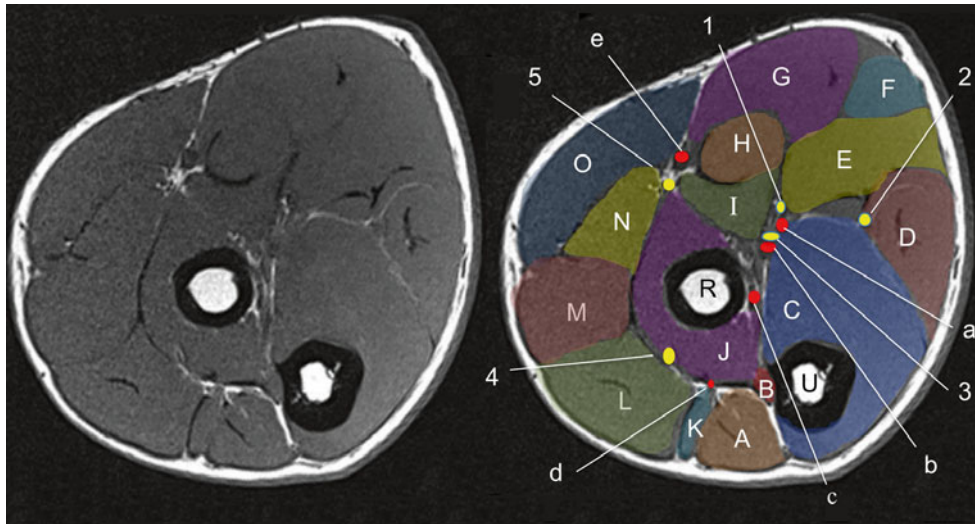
MRI axial image of the distal forearm. A anconeus muscle, B biceps tendon, C flexor digitorum profundus muscle, D flexor carpi ulnaris muscle, E flexor digitorum superficialis muscle, F palmaris longus muscle, G flexor carpi radialis muscle, H pronator teres muscle (humeral head), I pronator teres muscle (ulnar head), J supinator muscle, K extensor digiti minimi muscle, L extensor digitorum muscle, M
